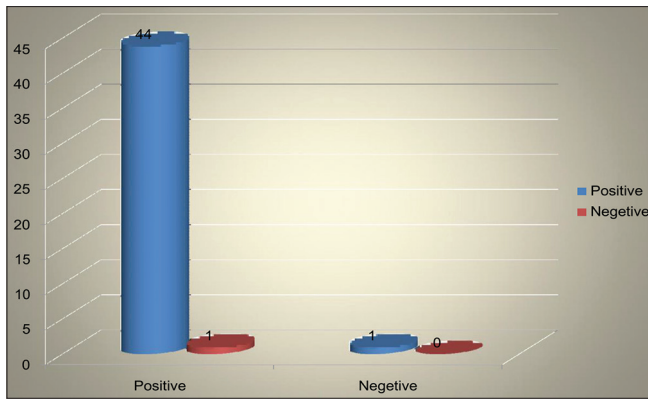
Diagnostic validity of high-resolution sonography
